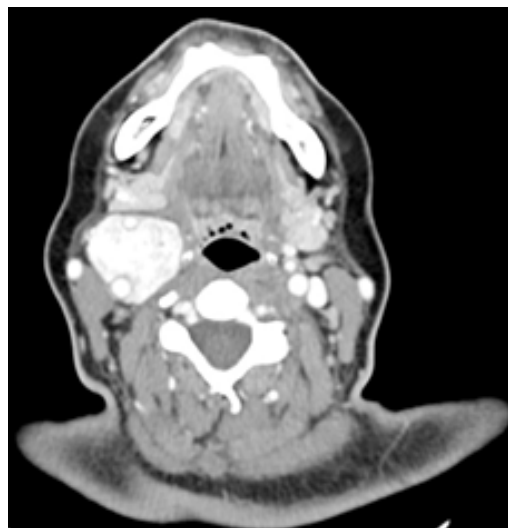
Axial soft tissue window, 2 mm slice thickness, contrast-enhanced CT.
